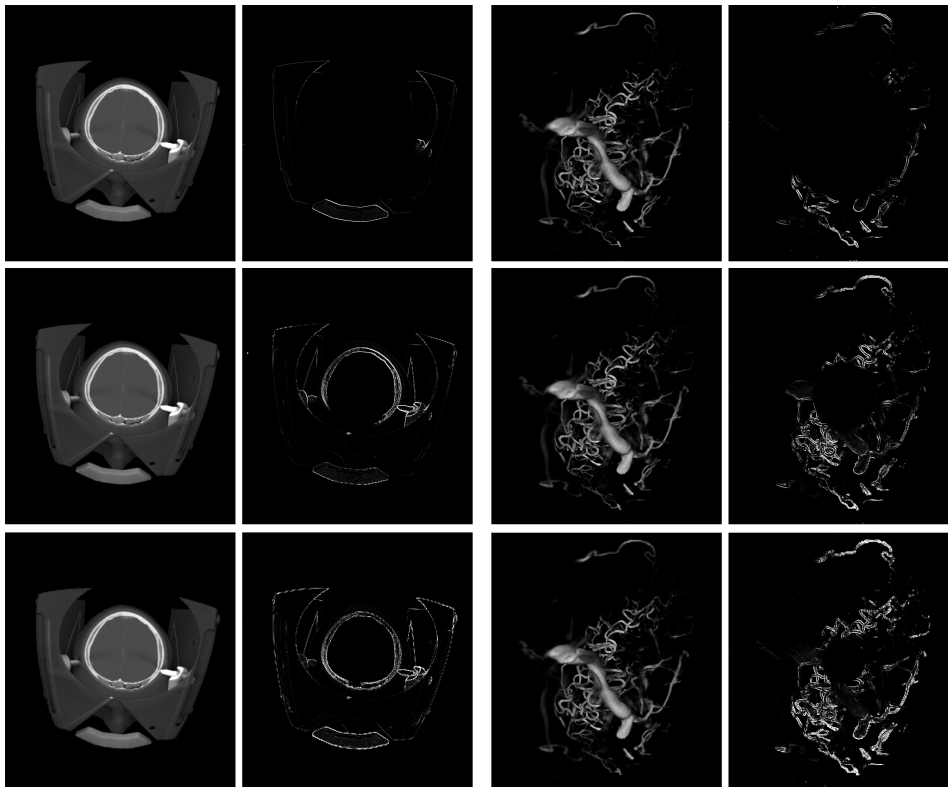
This image series represents three levels of the acceleration approach present in this work. The displayed image is a MRI scan on the left and a contrast enriched CT scan on the right. The bottom right images show the squared error compared to a native resolution rendering of the same viewport. The corresponding PSNR values are shown in Table 5.3.
